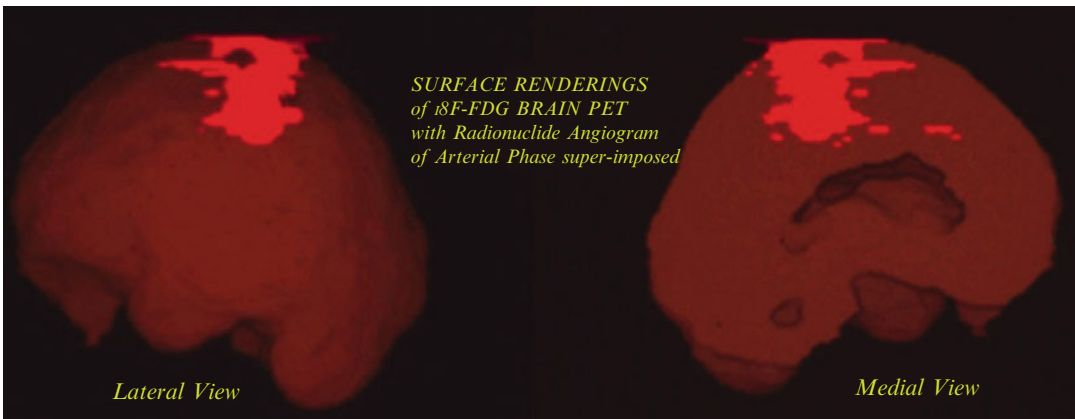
Arterial phase after 18F-FDG bolus injection outlining extent of the AVM shown in Fig. 3.28
